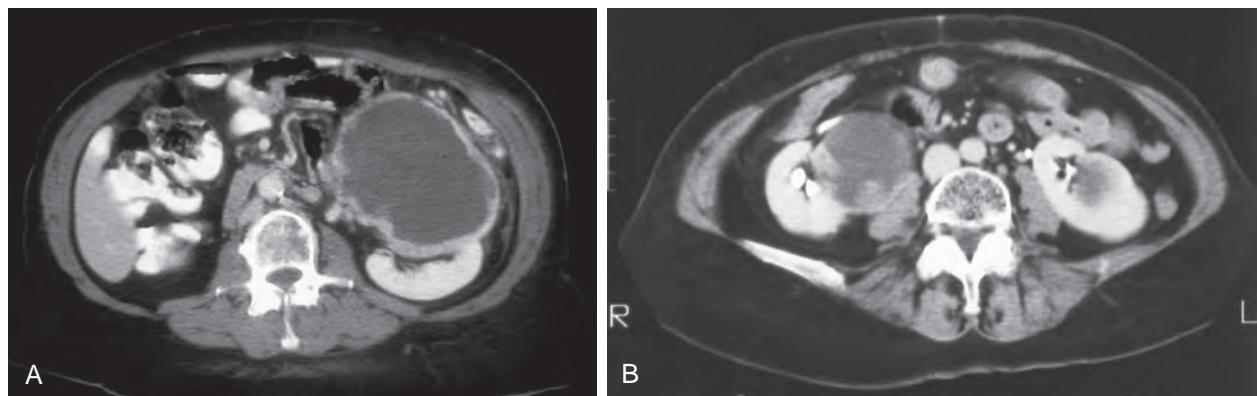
Bosniak category IV cysts. A, Computed tomography (CT) scan shows complex left renal cystic lesion with thick, enhancing walls. B, CT scan shows complex right cystic lesion with enhancing nodular areas and inhomogeneity. Both lesions proved to be renal cell carcinoma.
